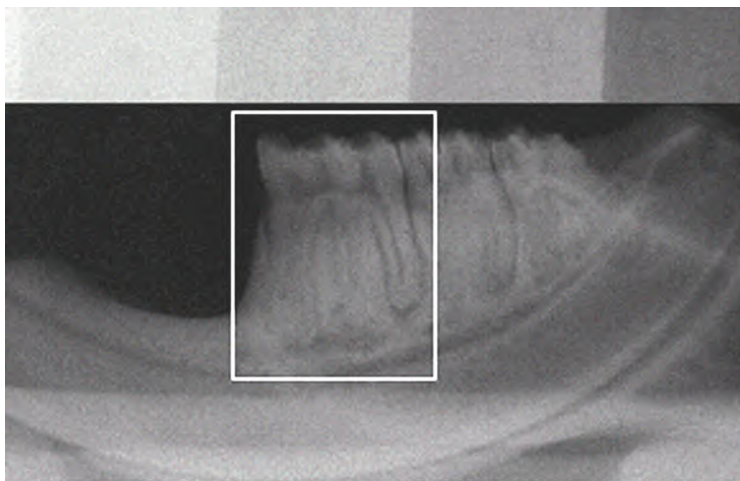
Radiograph of the mandibular first molar
